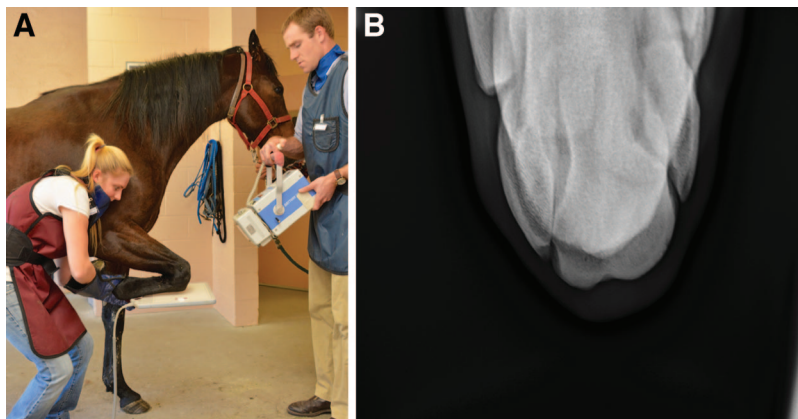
Routine radiographic projection of the carpus: View of the dorsal proximal–dorsal distal oblique–distal row of carpal bones.
